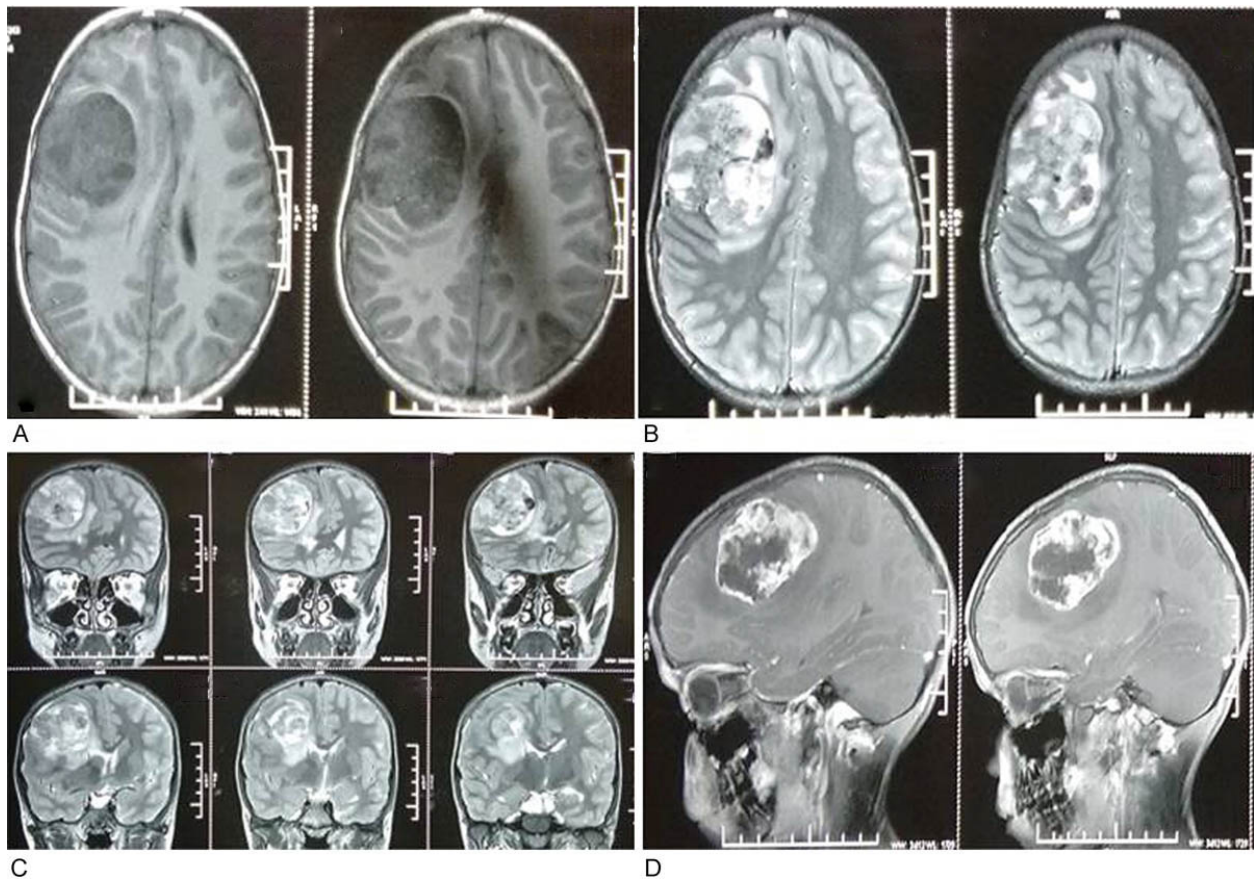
MRI (A) T1 axial. (B) T2 axial. (C) T2 coronal. (D) Contrast.
